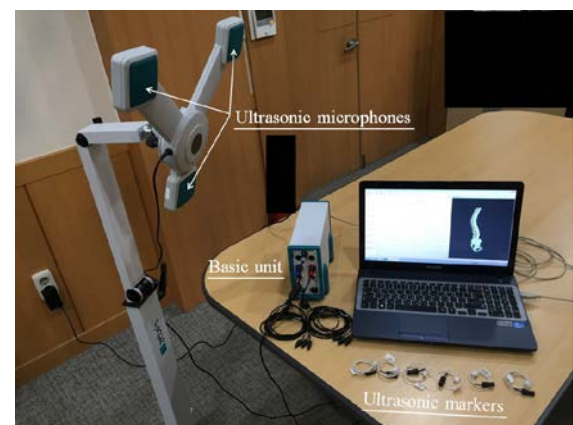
Ultrasound-based motion analysis system
